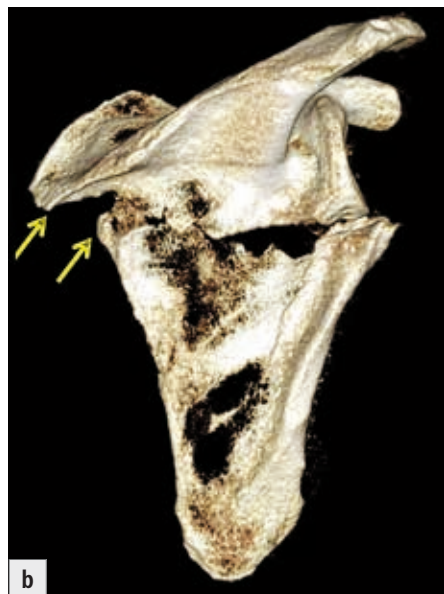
Medirolateral translation of fragments in an infraspinous two-part fracture of the scapular body on 3D CT reconstructions showing lateral displacement of the distal fragment: a) posterolateral view; b) posterior view; c) anterior view.
